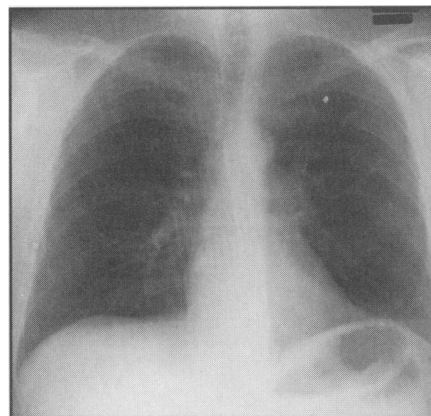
Chest radiograph 2 months after discharge.
